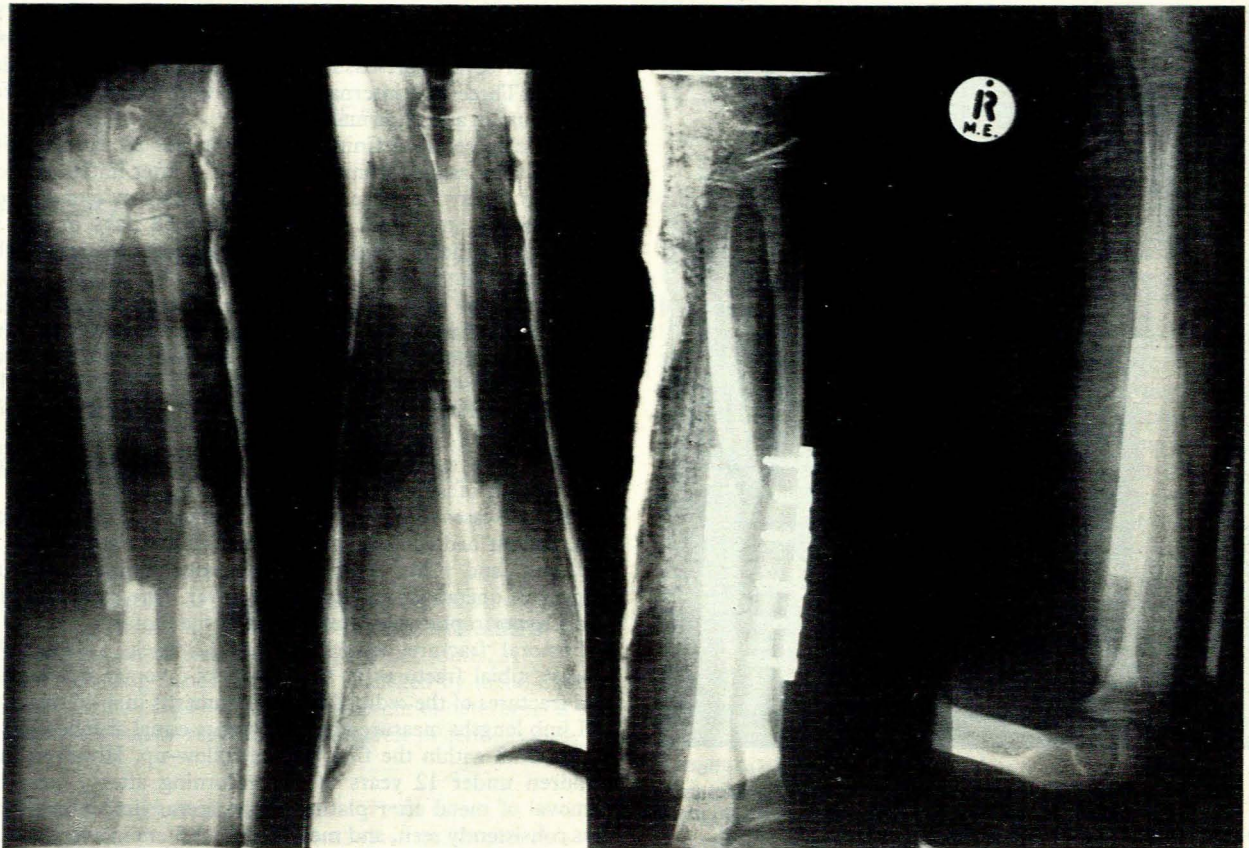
Difficulty was experienced with closed reduction of this forearm injury in a 12-year-old girl (left). Fixation of the radius only was performed (right: radiograph at 2 weeks), with excellent return of function.
